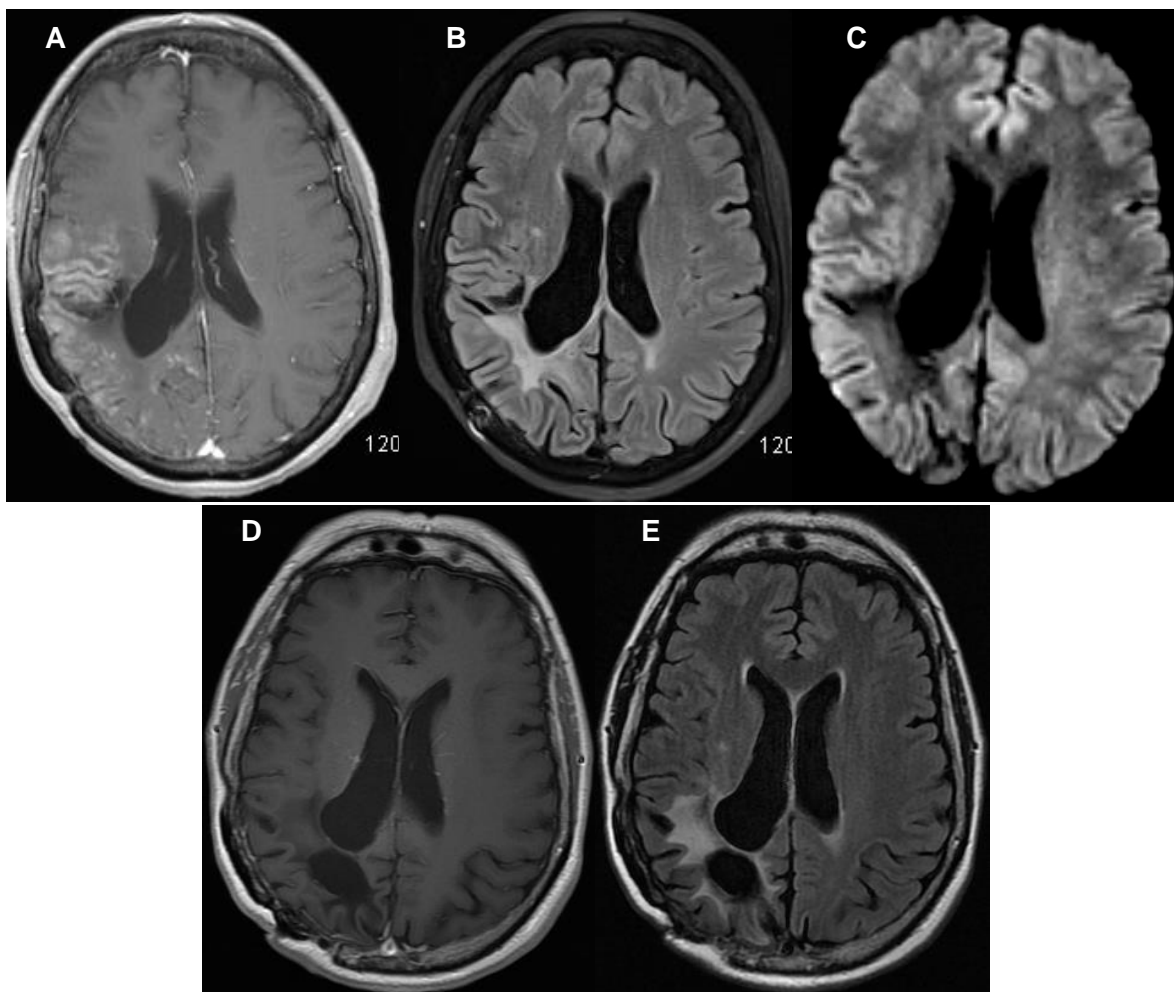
Brain magnetic resonance imaging (MRI): (A) Axial T1-weighted post-contrast, (B) Fluid-attenuated inversion recovery (FLAIR) and (C) Diffusion-weighted imaging showed gyriform enhancement in the right parietal and temporal lobes (thin arrow) with associated gyral swelling overlying the site of previous surgery (thick arrow). (D) T1-weighted post-contrast and (E) FLAIR repeat imaging 6 months later, demonstrated complete resolution of the above-mentioned findings.
